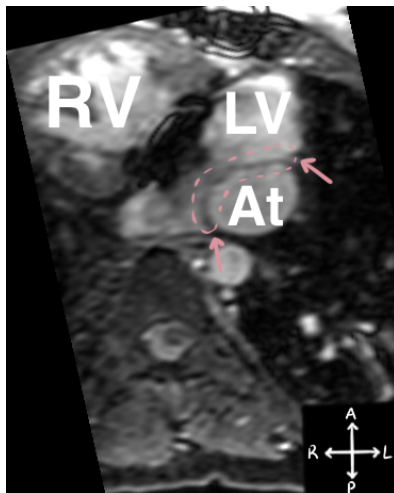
MRI scan of a heart of a patient with complex CHD. It that shows the present dextrocardia (the apex points towards the right) and the only atrioventricular valve (pink circle and arrows). Axial view.
